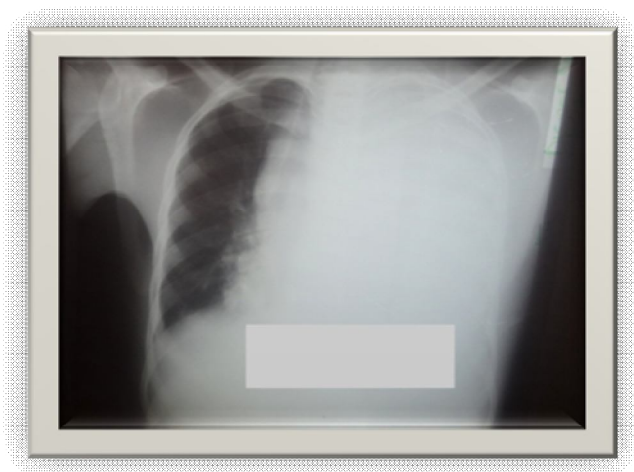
Supine chest radiograph of a 22 year old male with left haemothorax
